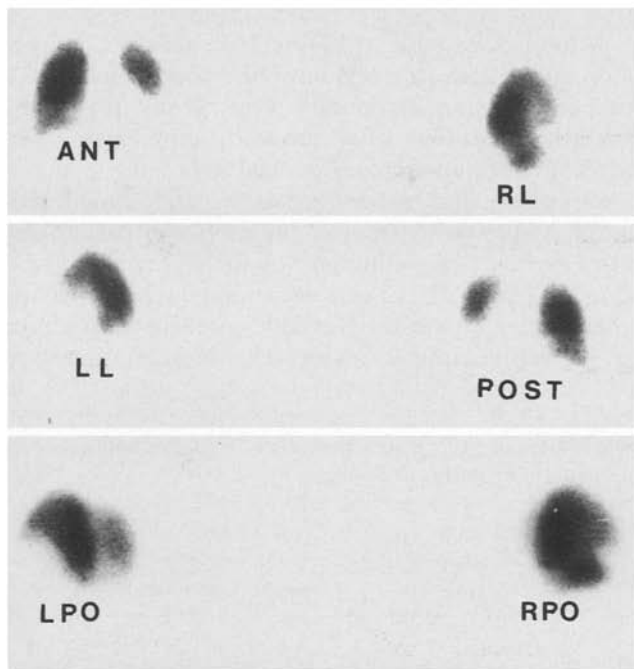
^{99m}Tc -MAA perfusion scintigram demonstrating a lobar defect involving the left lower lobe as well as subsegmental defects in the right lung. *ANT*, anterior; *POST*, posterior; *RL*, right lateral; *LL*, left lateral; *RPO*, right posterior oblique; *LPO*, left posterior oblique
